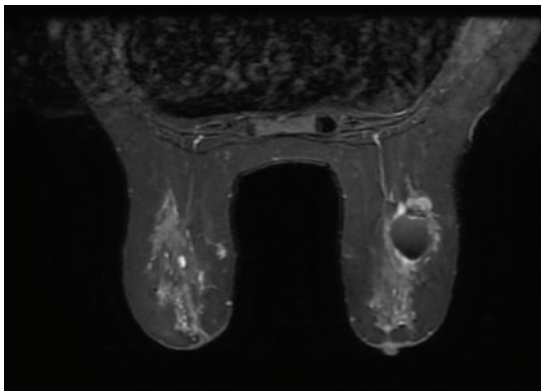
Patient's 2022 MRI image.
